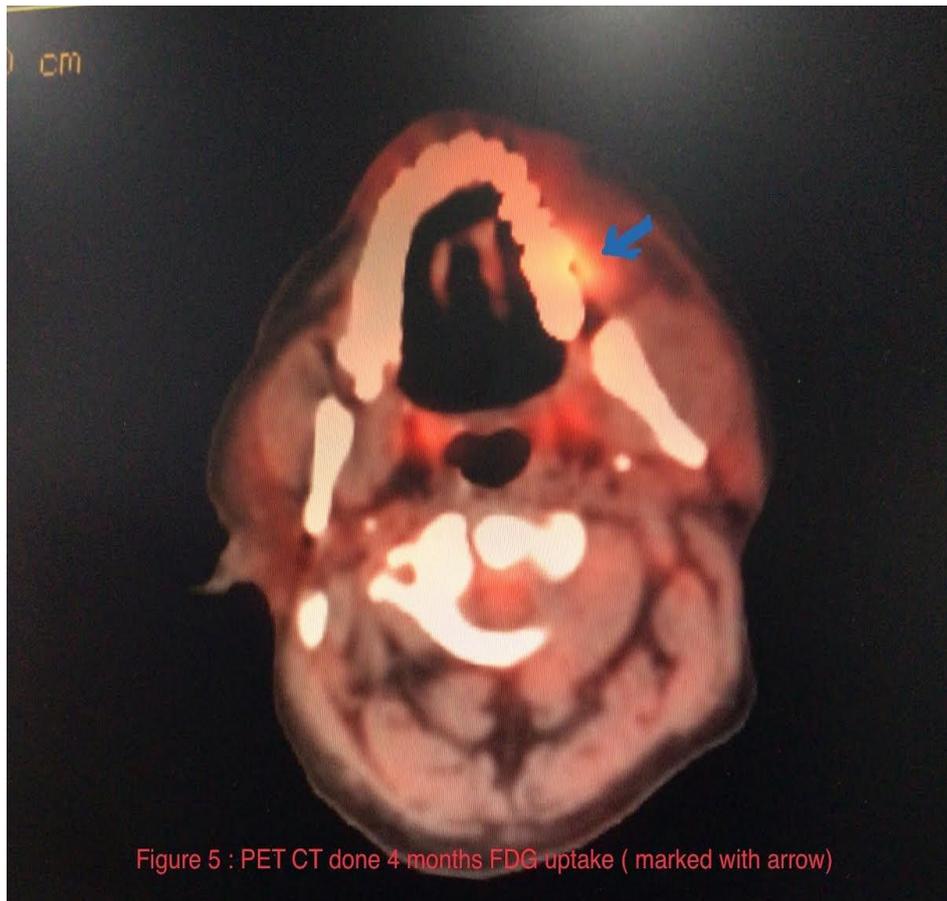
PET CT done 4 months FDG uptake (marked with arrow)
